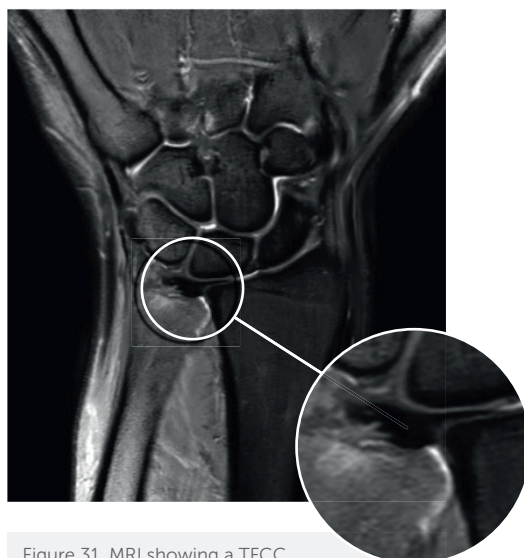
MRI showing a TFCC foveal avulsion.
